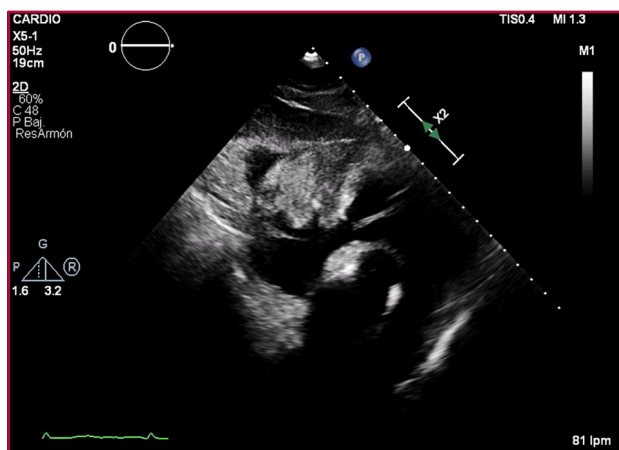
Transthoracic echocardiography, subcostal access. Heterogeneous, solid mass in the anterior pericardial sac, compressing the atrioventricular groove and appearing to adhere to the ventricular wall.
